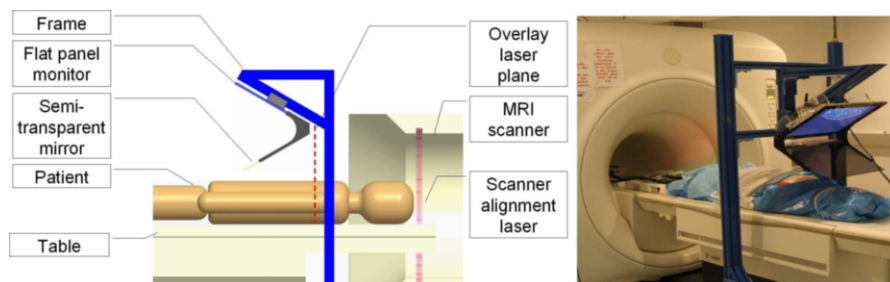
System concept of 2D image overlay device (left) and MRI image overlay device layout (right)
